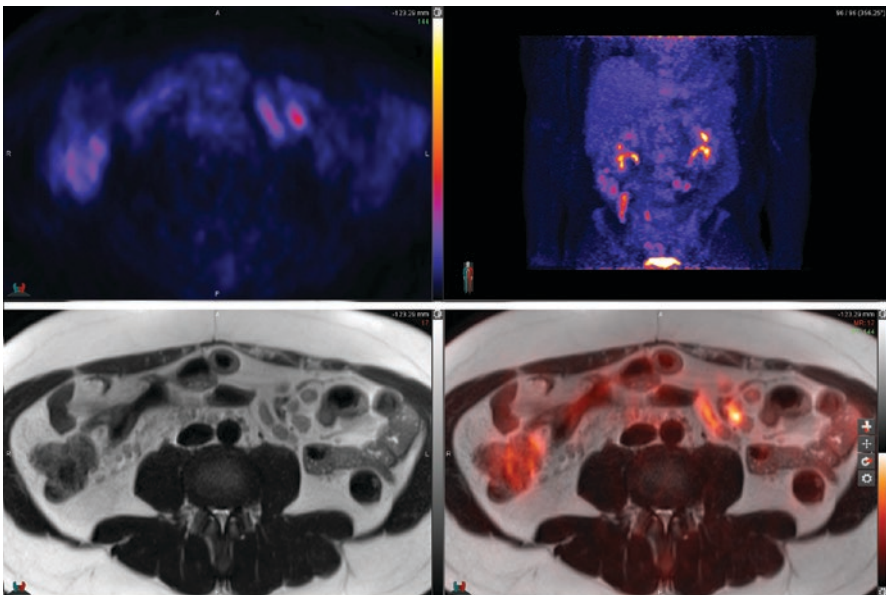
51-year-old male with follicular lymphoma. FDG PET/MRI demonstrates mild FDG uptake within mesenteric adenopathy (upper left frame), well delineated on axial HASTE MR (lower left frame)
